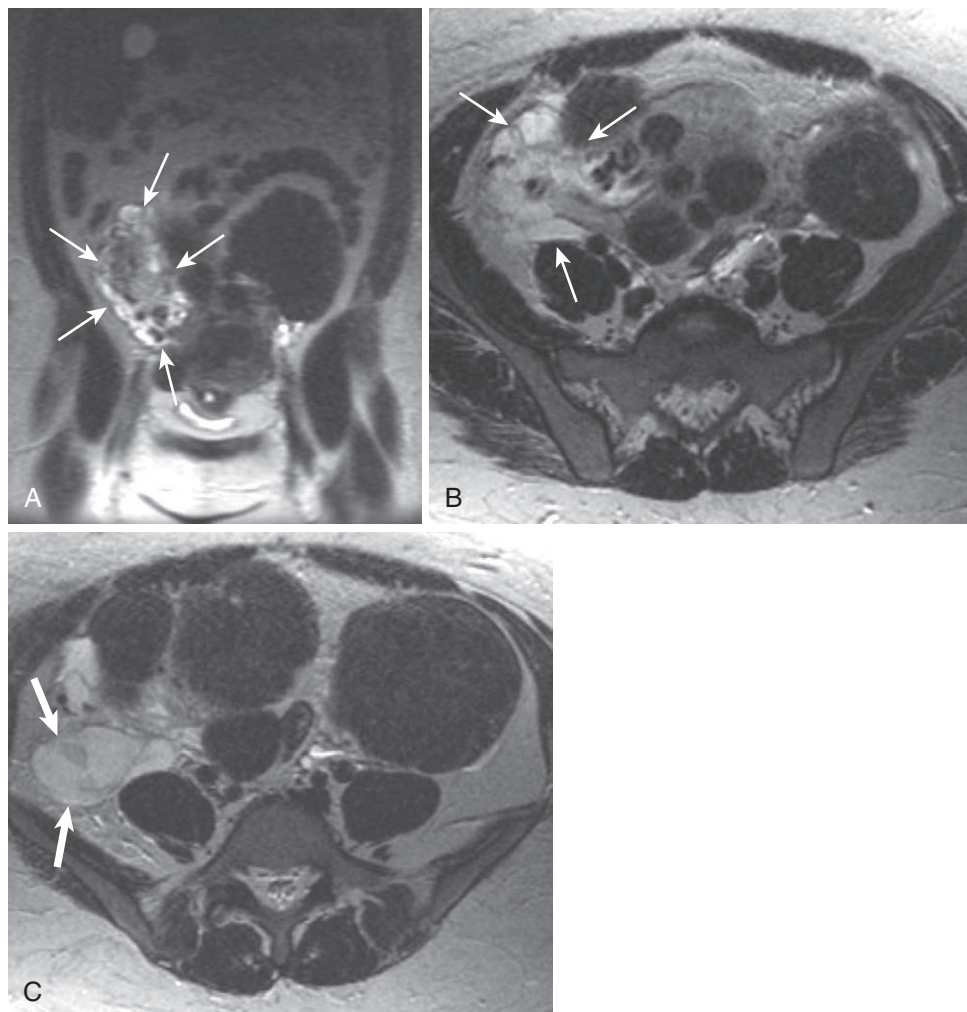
Edema associated with tubo-ovarian abscess (TOA) or acute adnexal pathology. A, Coronal T2-weighted image. Unilateral edema (*arrows*) in a young female with acute symptomatology practically limits diagnostic consideration to acute inflammatory pathology, including appendicitis and other gastrointestinal conditions and acute adnexal conditions. B and C, Axial T2-weighted images showing asymmetrical edema (*thin arrows* in B) emanating from a complex cystic fluid collection in the right adnexa (*thick arrows* in C), in the absence of bowel pathology (and the appropriate clinical findings), which indicates pelvic inflammatory disease.
